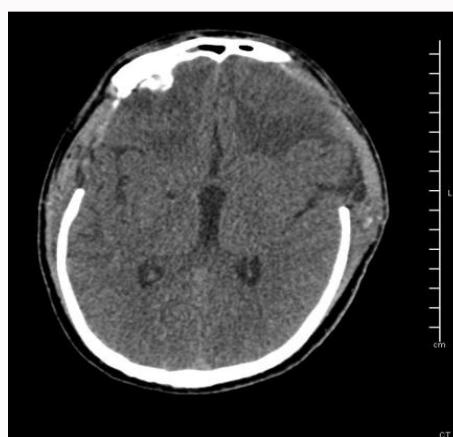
Follow up axial CT scan at the same level, showed regression of cerebral and basal ganglia hemorrhages with residual gliotic changes.
